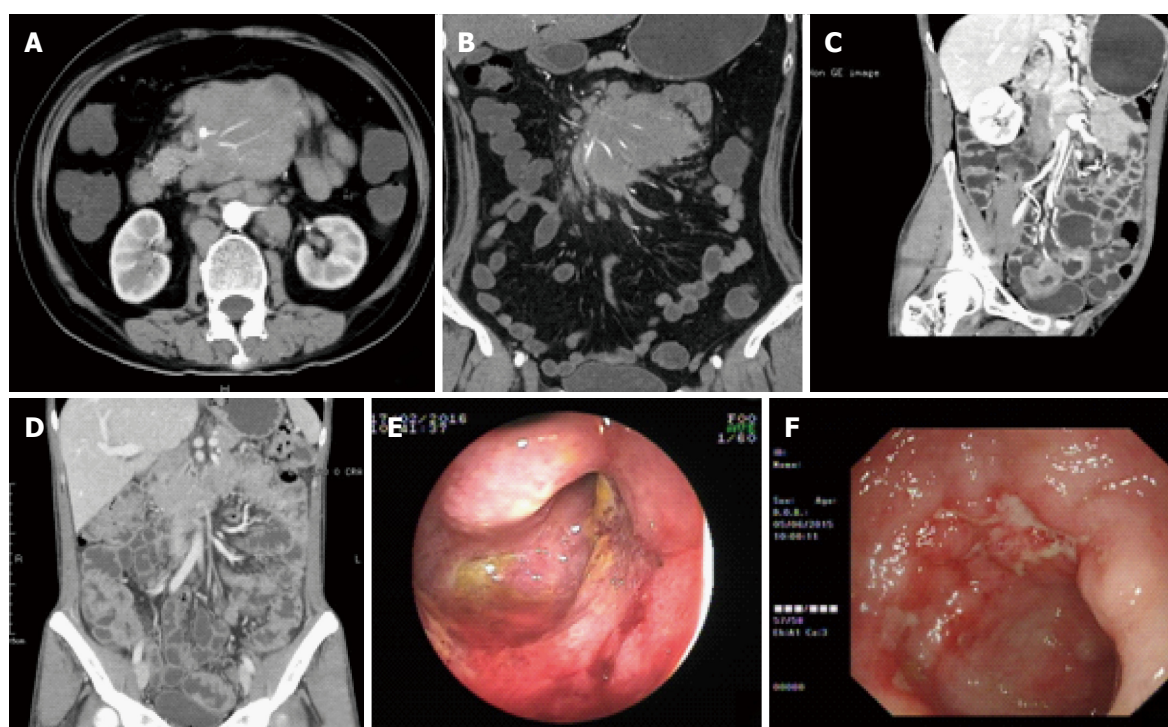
Endoscopic and computed tomographic enterography features in primary intestinal lymphoma. A and B: Axial and coronal reconstructed CTE sections showed mass of sandwich sign in mesentery area; C: Coronary reconstructed CTE reflected aneurysmal dilation in pelvic intestine; D: Coronary reconstructed CTE displayed circular thickening of bowel wall without stricture in ileocecal region; E: DBE showed intraluminal proliferative mass in proximal ileum; F: Colonoscopy revealed irregular ulcer in ileocecal region.
